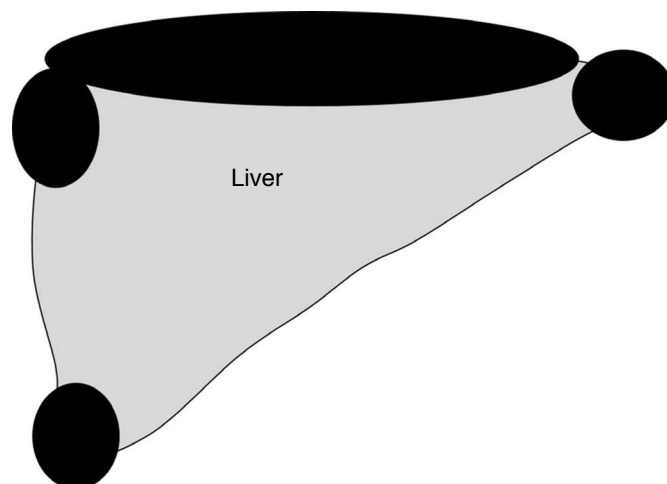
Subcapsular areas where hepatocellular carcinoma can be missed easily by ultrasonography (US). Some subcapsular areas (shown in black) may not be visualized on US, especially in obese patients.
